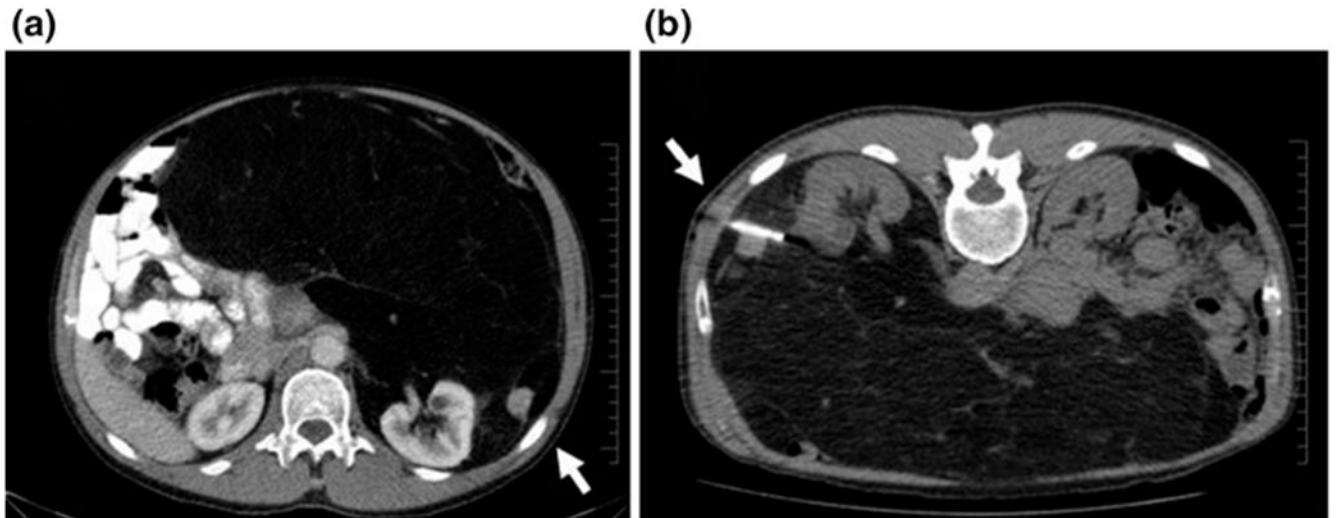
CT-guided percutaneous core needle biopsy of a large lipomatous tumor arising from the left retroperitoneum. CT guidance facilitated targeted sampling of the more solid area within the mass (a white arrow shows the location of this area on diagnostic CT; b, core needle is indicated by the white arrow), yielding a diagnosis of low grade dedifferentiated liposarcoma. The optimal treatment strategy was then discussed at Multidisciplinary Sarcoma Tumor Board. *CT* computed tomography
